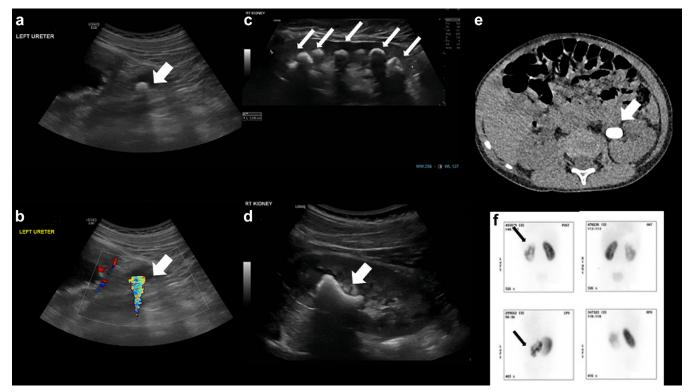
Examples of imaging in pediatric stone disease. (a) Ultrasound of the urinary tract. Note the echogenic focus (arrow) within the proximal ureter which demonstrates posterior acoustic shadowing, suggesting a stone. (b) Same patient, but now color Doppler applied. Note the "twinkle" artifact (arrow), a focus of alternating colors behind a reflective object. (c) Ultrasound of the right kidney in a patient with primary hyperoxaluria. Note the dense medullary nephrocalcinosis (arrows), some with acoustic shadowing, consistent with stone formation. (d) Ultrasound of the right kidney with a Staghorn calculus (arrow) occupying the renal pelvis and upper pole calyceal system. (e) Example of a large calculus (arrow) in the left pelviureteric junction, as seen on computed tomography. (f) Dimercaptosuccinic acid imaging of the same patient as in (e) shows associated focal scarring in the left upper and lower pole.
